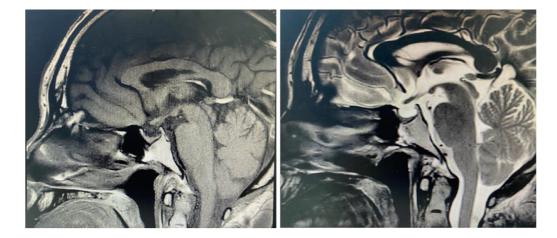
Pituitary magnetic resonance imaging showing vacuolar sella, thinned pituitary stalk, and bilateral maxillary sinus cyst.
